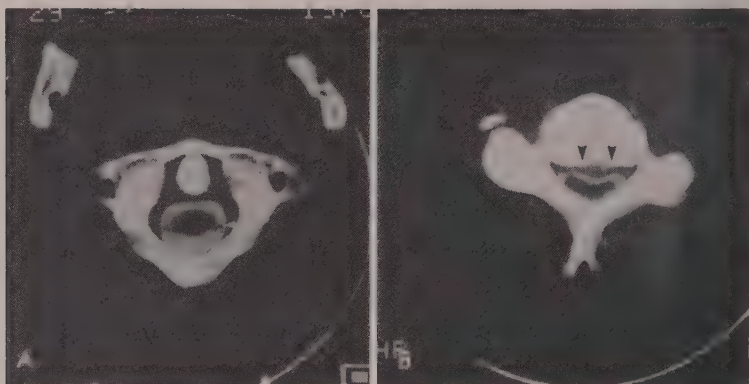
Metrizamide CT of the Spinal Canal. A, Normal.* At the level of the C1 ring and dens, NCT reveals the whole halo of the metrizamide-opacified subarachnoid space, the central spinal cord and the posterior nerve roots bilaterally (little white arrow). The cervical epidural space appears lucent with respect to the metrizamide-opacified cerebrospinal fluid, but is denser than nonopacified cerebrospinal fluid (see Figure 18A). *B, Cervical disk.* At the level of the C3-C4 intervertebral disk space, CT reveals marked posterior displacement of the metrizamide-opacified cerebrospinal fluid and the cervical spinal cord by a large, partially calcified cervical disk (arrowheads).
